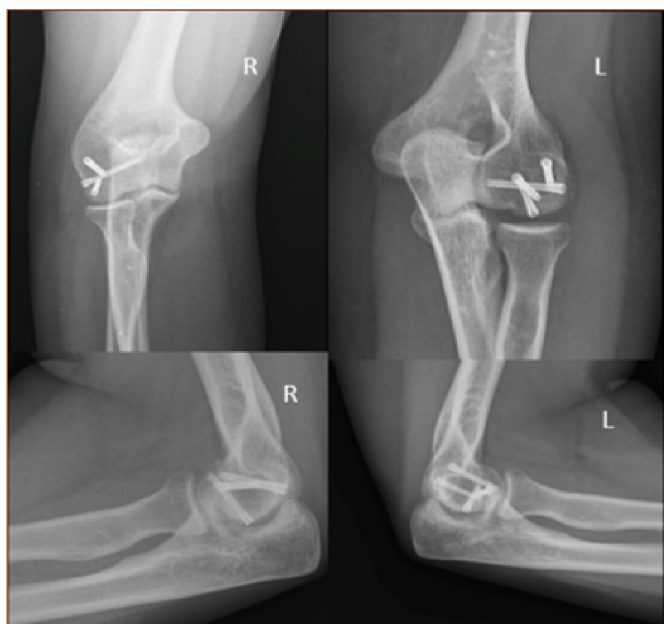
Postoperative 12. Week control X-ray
